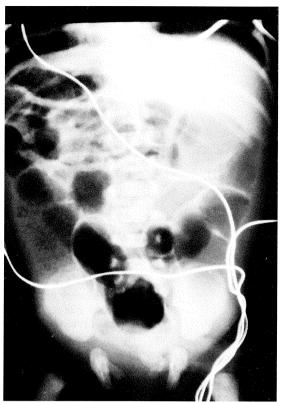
Abdominal radiograph showing dilated small and large bowel loops filled with gas without air-fluid levels.
